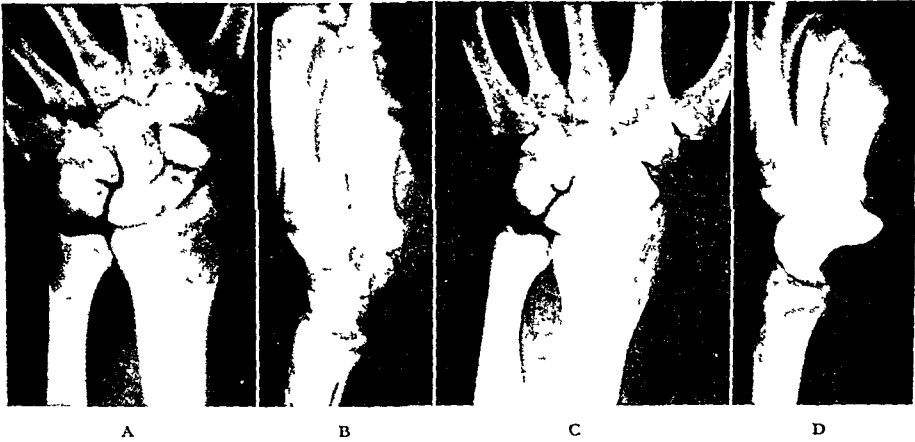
Roentgenogram showing fracture of carpal scaphoid; A and B, before operation; C and D after operation; (vitallium prosthesis replacement after excision).
